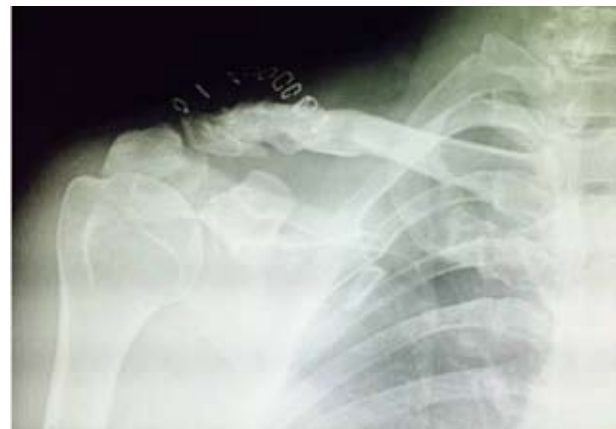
A radiograph after hook plate removal showing the union of both fracture sites (distal clavicle fracture and clavicle fracture at medial end of the hook plate).
